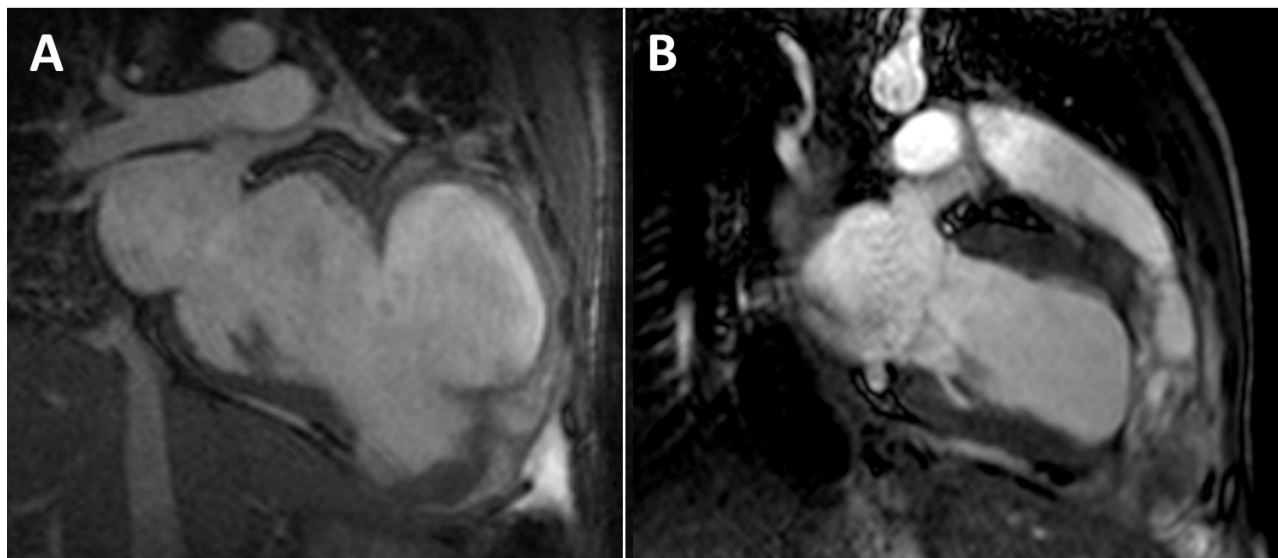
A: Pseudoaneurysm in anterior, anteroseptal and apical region of the left ventricle in MRI. B: Left ventricle after surgery with geometrical correction.
